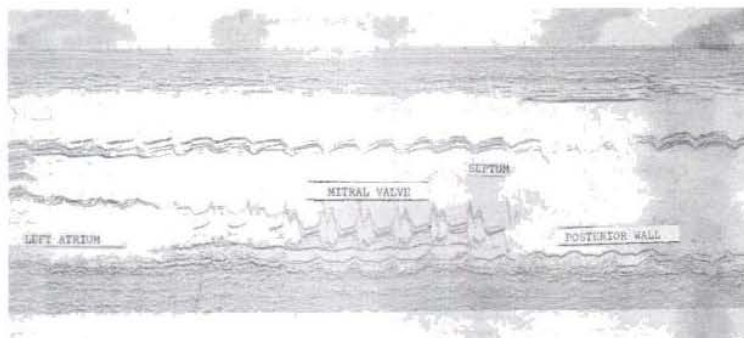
Echocardiogram: Scan from aortic root to left ventricle reveals generalized chamber dilatation and decreased wall motion.
